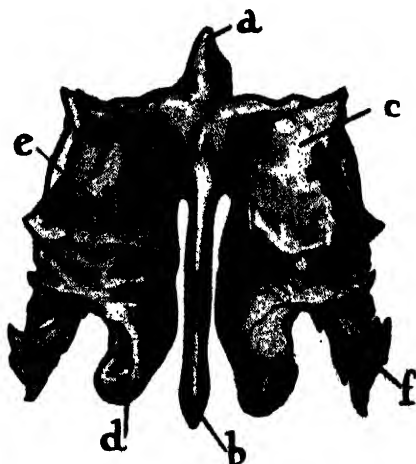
ETHMOIDAL BONE. POSTERIOR ASPECT.
